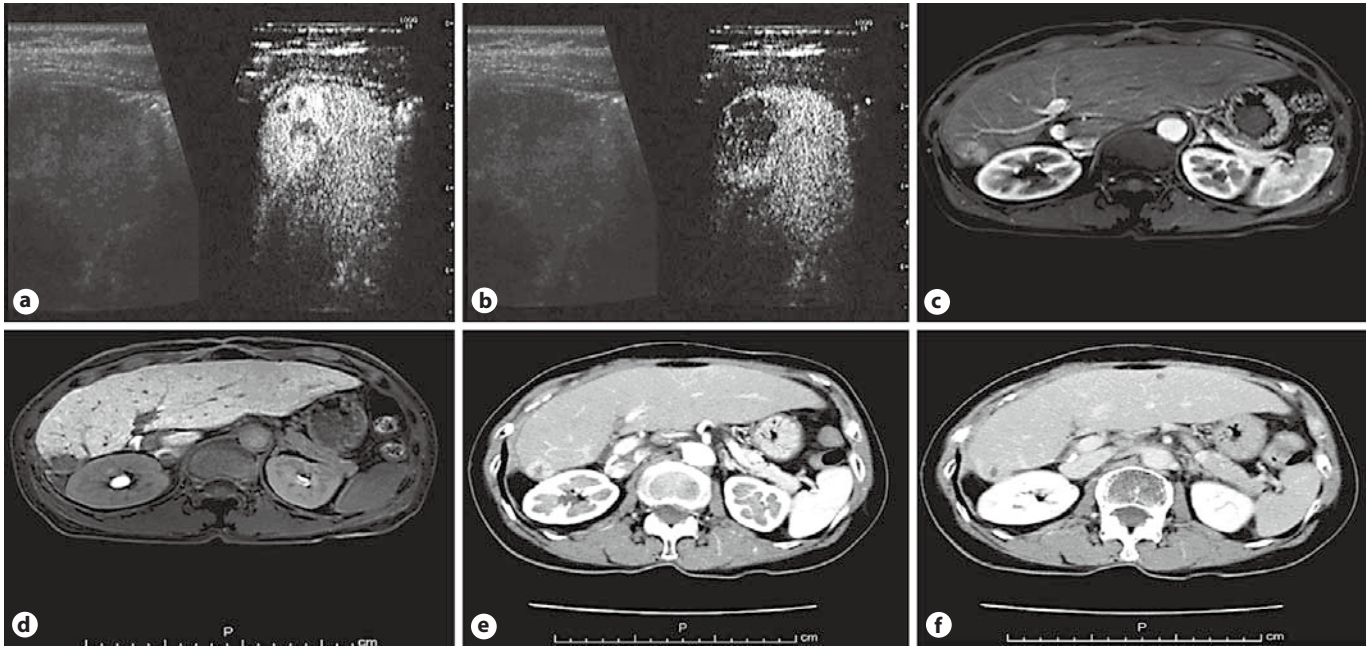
Detection by Sonazoid-enhanced US, Gd-EOB-DTPA-MRI, and CECT. a Sonazoid-enhanced US revealed hypervascularity in the early vascular phase. b A defect in the Kupffer phase. c Gd-EOB-DTPA MRI revealed hypervascularity in the arterial phase. d A defect in the hepatobiliary phase. e CECT revealed hypervascularity in the arterial phase. f Washout in the portal phase.
